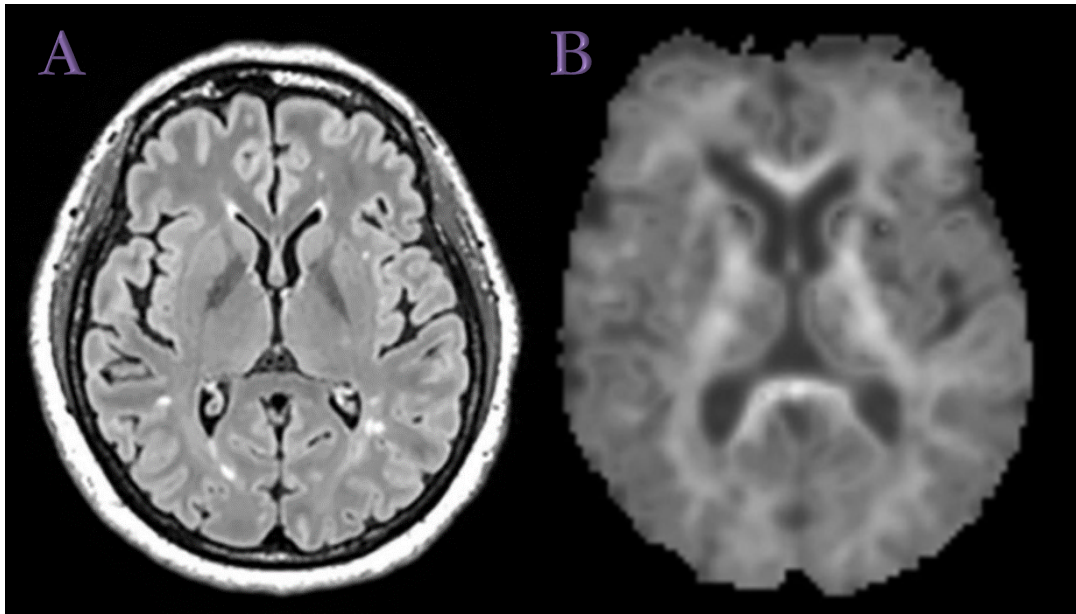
MR scans and lesion masks from a 53-year-old patient with relapsing-remitting multiple sclerosis. (A) Axial FLAIR image showing hyperintense lesions. (B) Mean kurtosis (MK) parametric map obtained using a DKI sequence.
